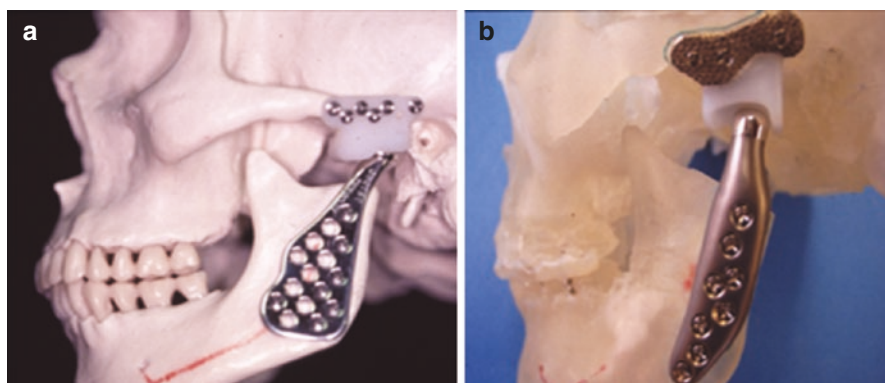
(a) Example of Biomet stock joint in which the patients bone is modified to fit the prosthesis, (b) example of TMJ concepts custom joint which is fabricated from the patient's CT that is made into a 3D reconstruction model
